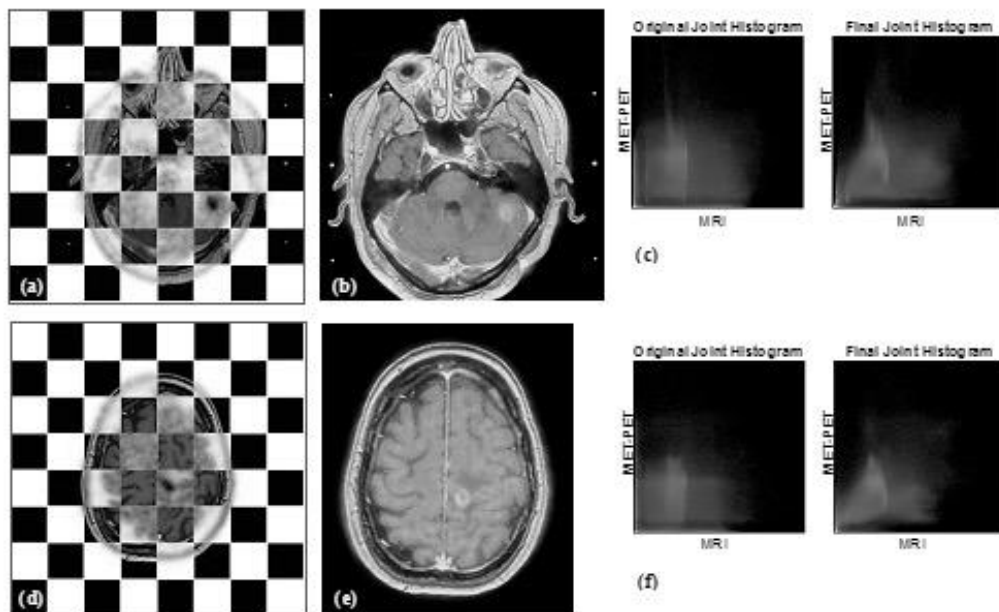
Instances of PET/MRI co-registration using SPM via maximization of NMI: (a, d) checkerboard images of co-registered PET and MRI; (b, e) fused images; (c, f) corresponding original and final joint histograms for (b) and (e), respectively.
